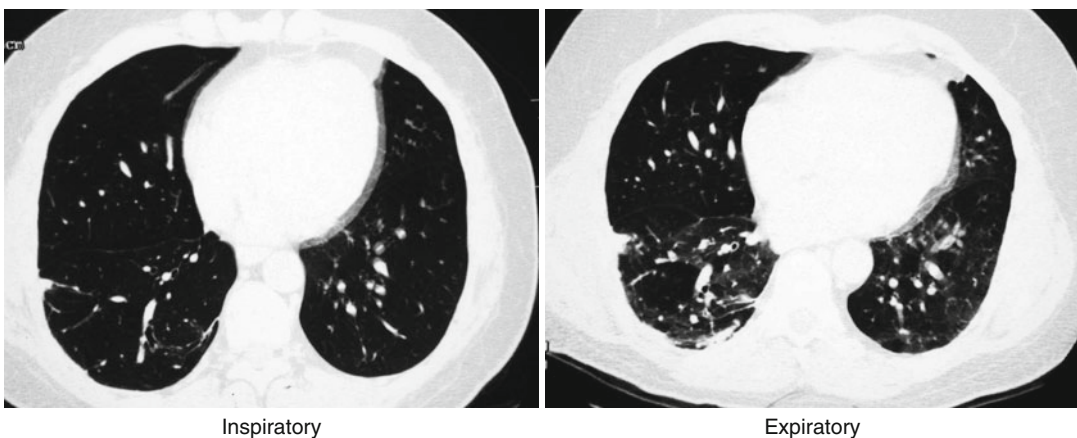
Computed tomography (CT) of bronchiolitis obliterans syndrome (BOS), inspiratory and expiratory films. Note bronchiectasis on both inspiratory and expiratory images
